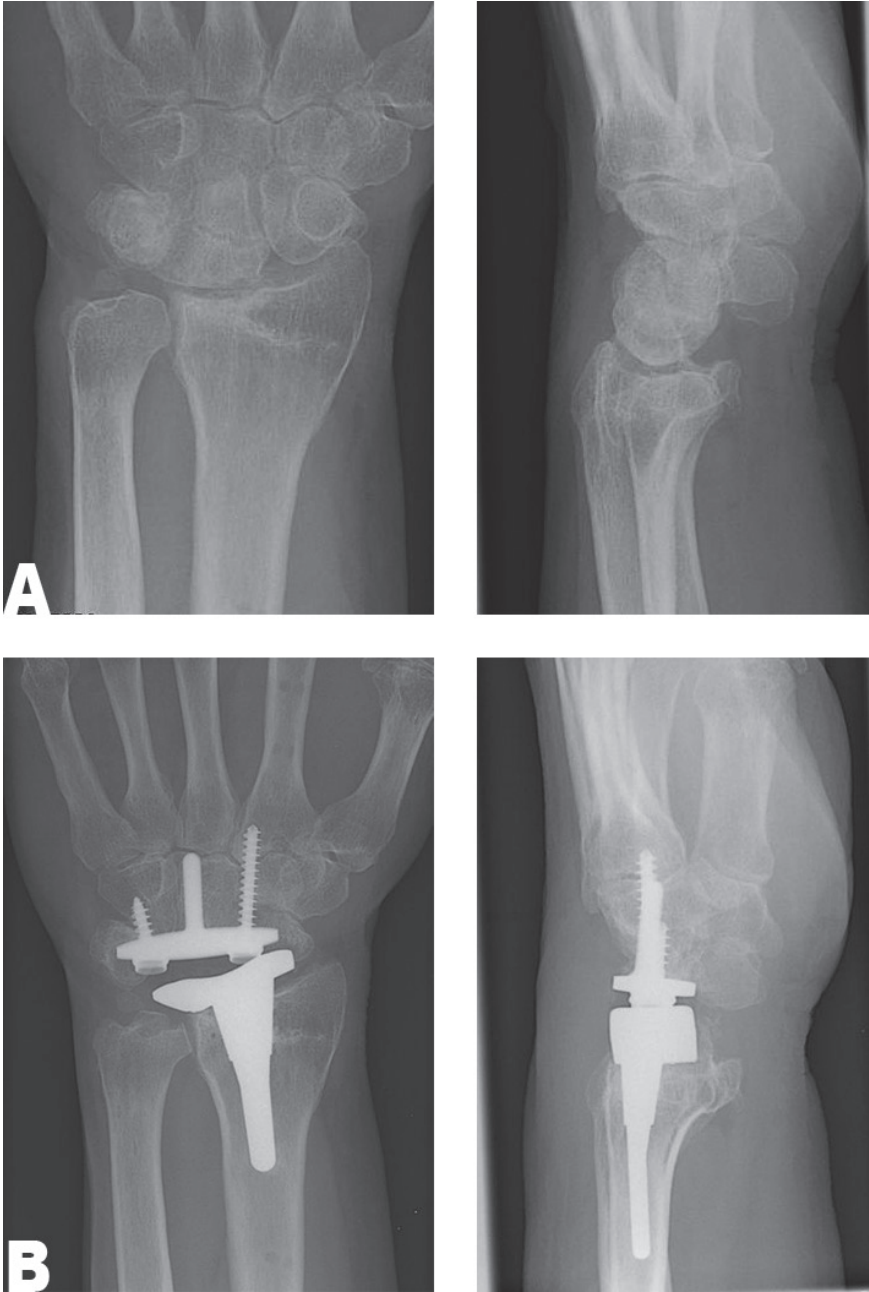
(A) Preoperative X-ray (PA and lateral view) of a patient with grade 4 osteoarthritis. (B) Postoperative X-ray (PA and lateral view) of the same patient 6 months after Universal 2 implant (Integra Life Sciences). PA: posteroanterior.
